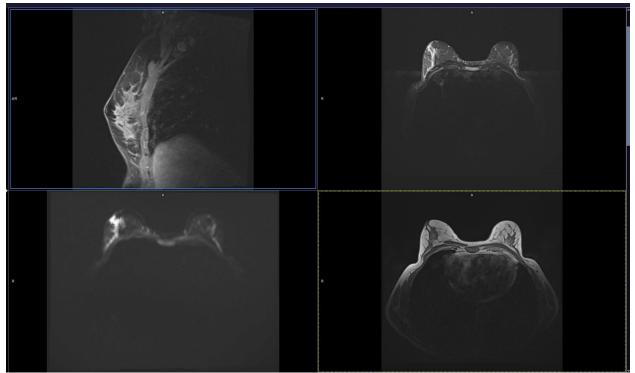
Breast MRI examination.
